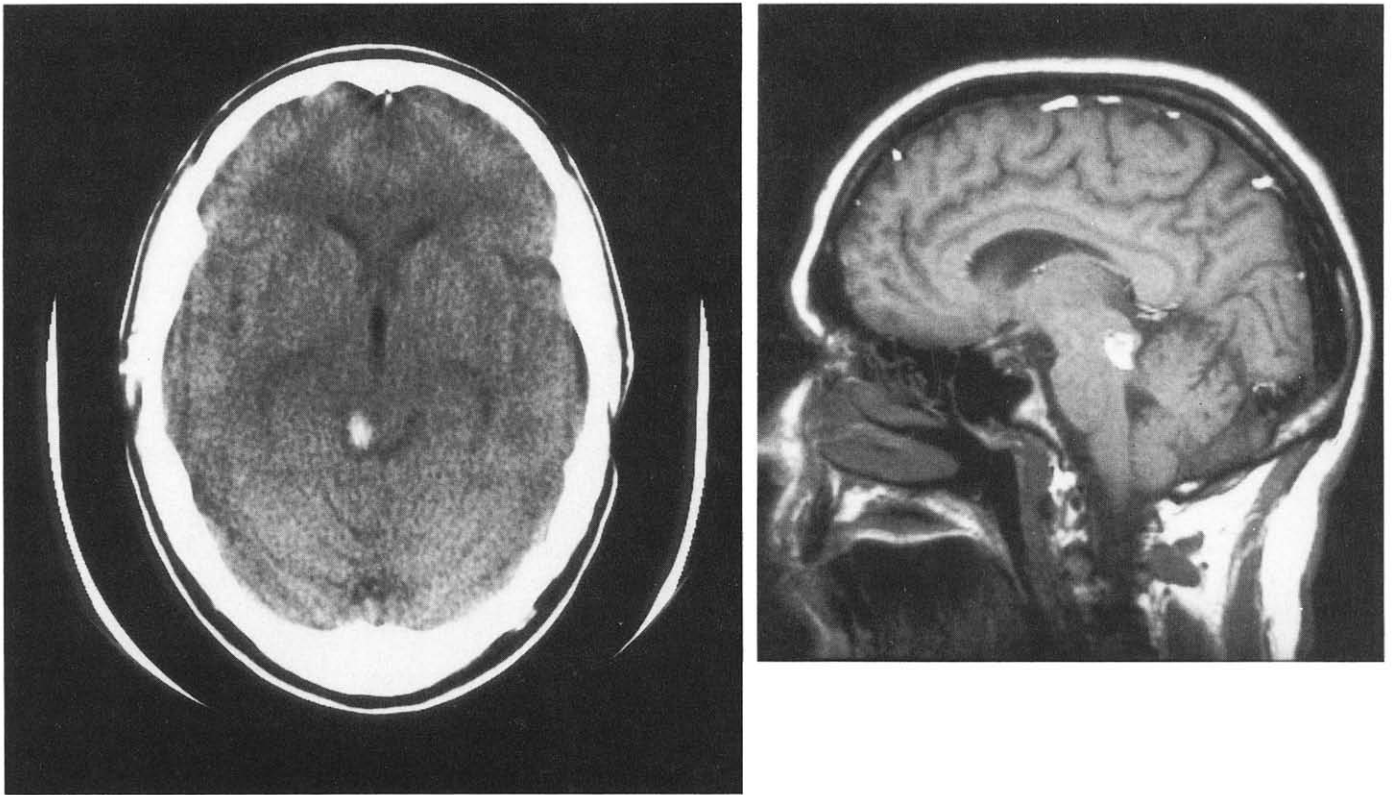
Case 4. (Left) Unenhanced CT scan on day of hemorrhage, showing hyperdense zone representing hemorrhage in right side of midbrain tectum. (Right) MRI scan 6 days later, showing hyperintense signal on short-TE/short-TR sequence within the inferior colliculus, consistent with a subacute or chronic component of hemorrhage.
